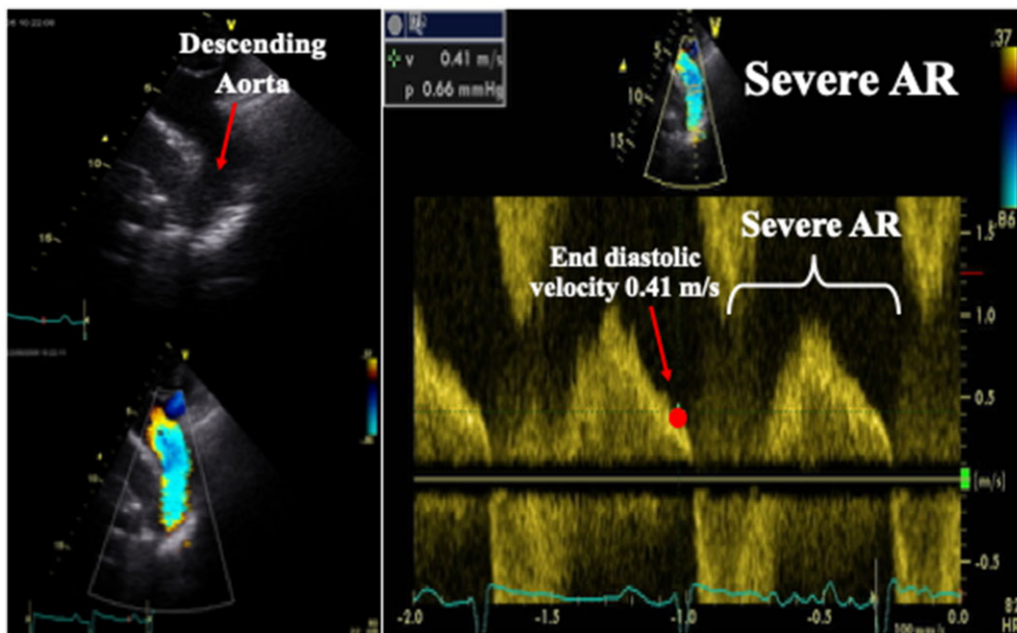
A pulsed Doppler recording within the descending aorta from a patient with severe AR demonstrates flow reversal throughout diastole. An end diastolic flow velocity greater than 20 cm/s is indicative of severe AR.
